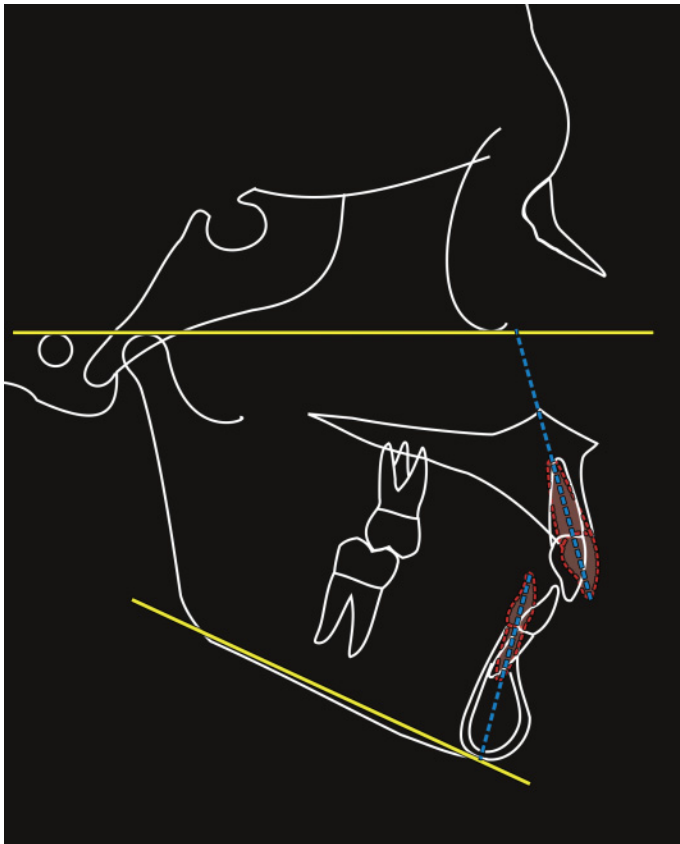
The Ballard conversion method to evaluate sagittal jaw discrepancy: The outlines of the maxilla, maxillary incisors, mandible and mandibular incisors are traced over the lateral cephalometric radiograph. The long axes of these teeth are drawn from incisal tip to root apex. The root centroid (centre of resistance) is identified as a pivot point, or point of rotation, about one-third to one-half of the root length from the root apex. The maxillary and mandibular incisor inclinations are corrected by rotating around the root centroid until the 'ideal' inclination is reached. The residual incisor overjet is taken as a reflection of the sagittal skeletal discrepancy, i.e. an increased overjet signifies a Class II skeletal pattern, and a reduced or reverse overjet a Class III skeletal pattern.
